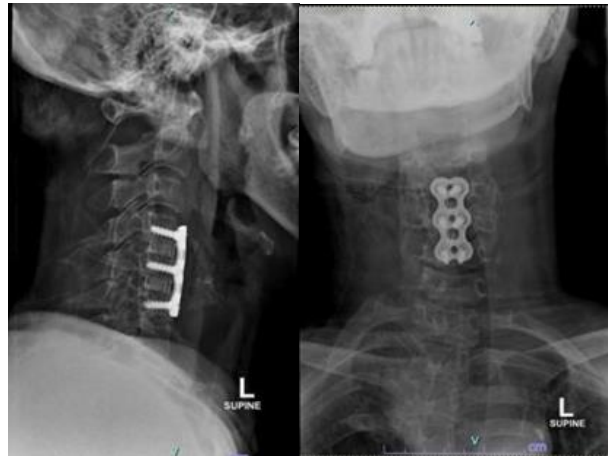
Cervical Xray post operation.
